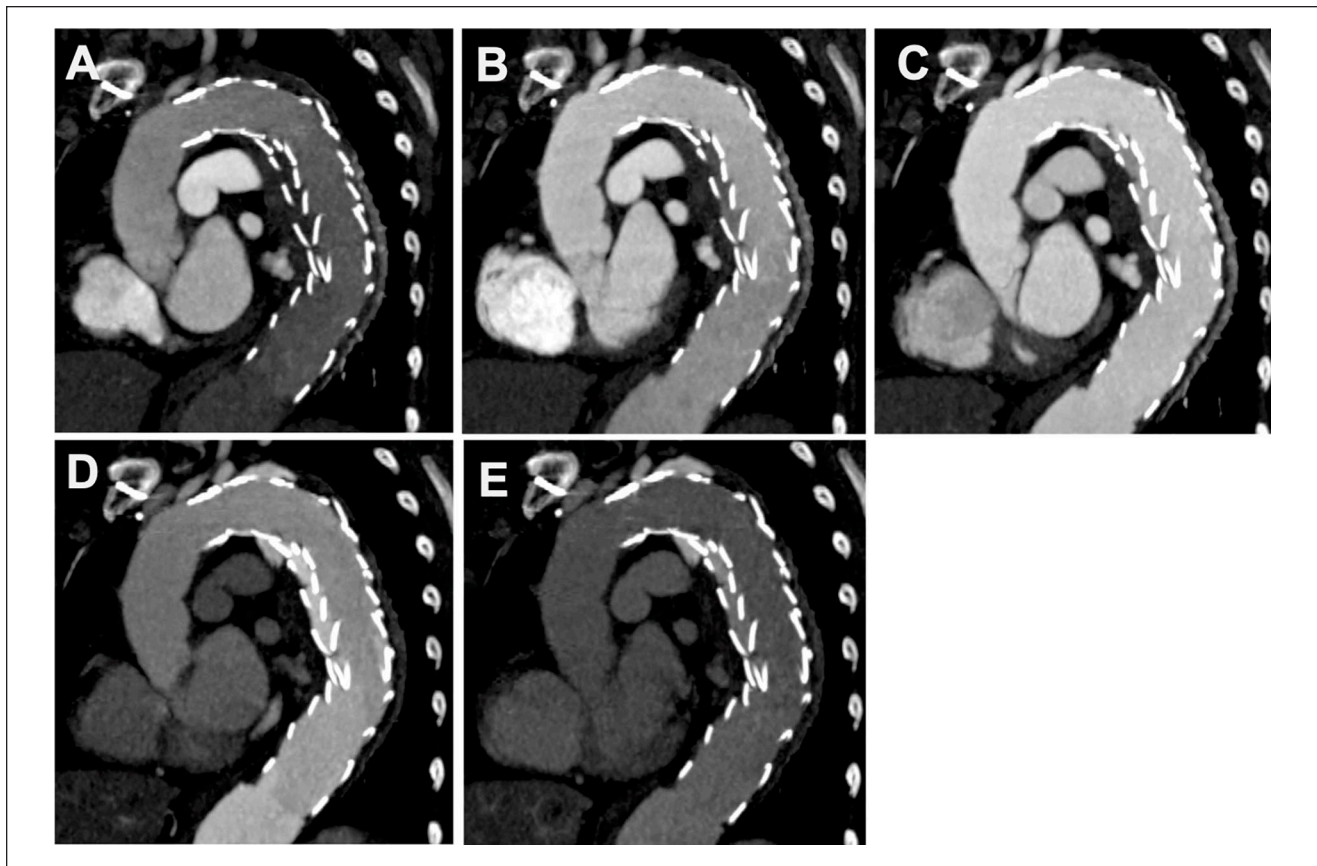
Angulated and time-resolved reconstruction of dynamic computed tomography angiography (CTA) after implantation of 2 overlapping TEVAR-stents. (A) First scan in the early phase with low contrast in the ascending aorta: No contrast agent between both stent grafts. (B) 1.4 seconds after the first scan—early arterial phase with increasing contrast throughout the aorta: Contrast agent between both stent grafts in the lower overlapping zone. (C) 4.2 seconds after the first scan—arterial phase with homogeneous contrast throughout the aorta: Contrast agent between both stent grafts in the upper overlapping zone. (D) 7.0 seconds after the first scan—Contrast agent propagation between both stent grafts into the aneurysm sac. (E) 12.6 seconds after the first scan—Contrast agent persists in the aneurysm sac and residually in the overlapping zone. There is no more contrast agent in the aorta. The endoleak was classified type 3a.
